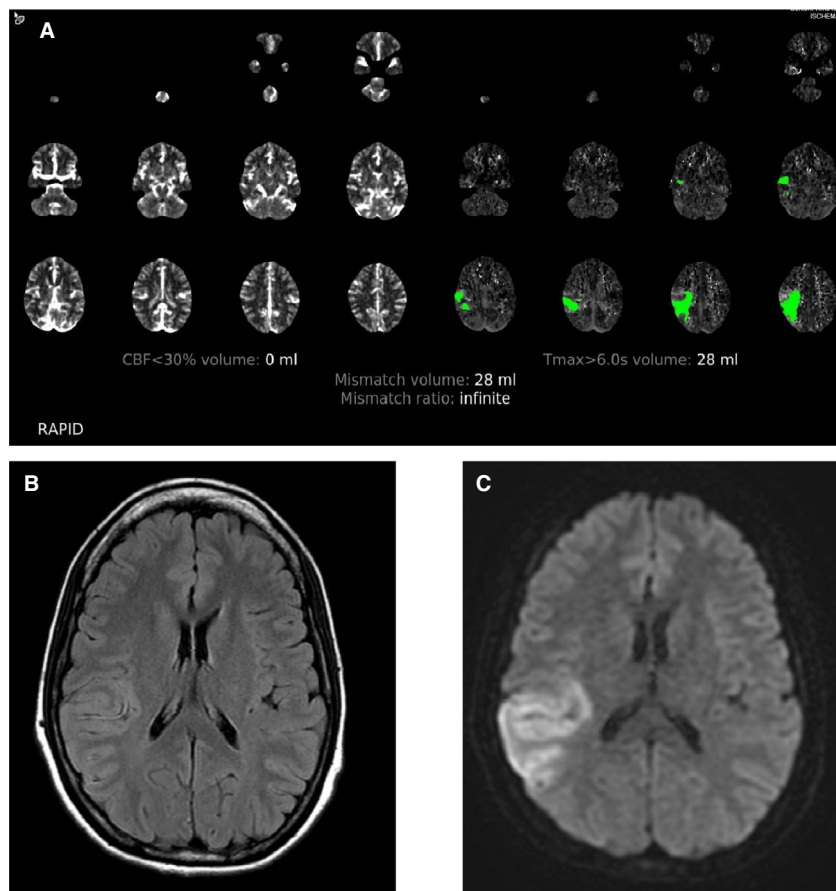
Patient imaging demonstrating criteria for extended window IV rt-PA. (A) Initial CTP (using RAPID software) showing perfusion deficit of 28 ml in green on the right; no core 0 ml usually represented in magenta. (B) Initial MRI showing no T2 changes on FLAIR. (C) Initial MRI showing restricted diffusion on DWI.
